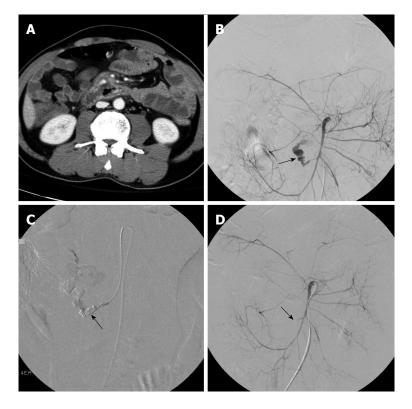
Images from a 36-year-old woman with a history of abdominal trauma (hemoglobin, 7.1 g/dL; hematocrit, 24.5%). A: 64-row computed tomography angiogram in arterial phase showed a focus of extravasation in the ileum (arrow); B: Active bleeding site was found on conventional angiography; C, D: Post-embolization angiography confirmed complete occlusion of the active gastrointestinal bleeding with coils (arrow).
